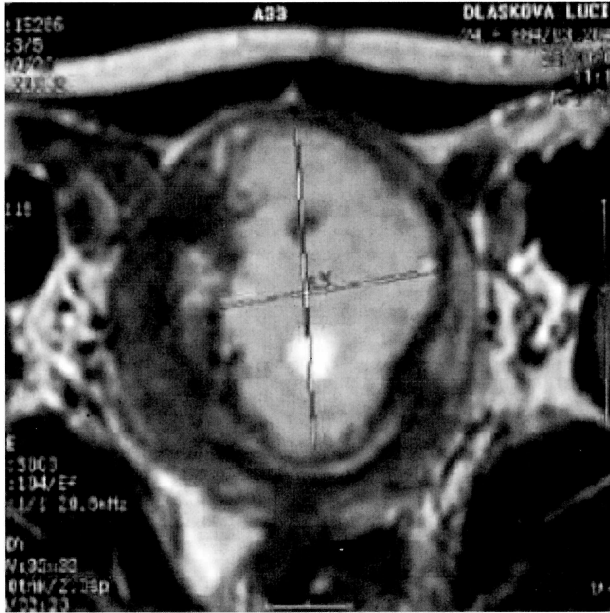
MRI demonstrates hyperdense multilocular fibroid lesions with peripheral hemorrhage.
